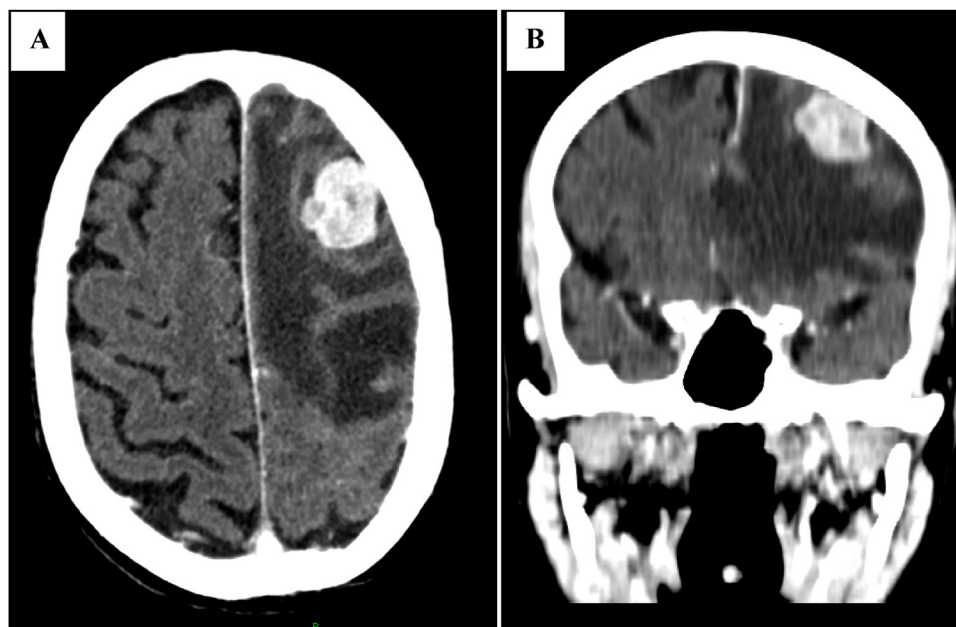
Coronal [A] and axial [B] views of the head CT scan demonstrating a single frontal metastatic lesion.
